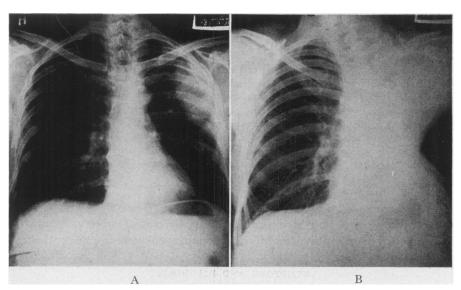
(A) Case 7: Regular PA roentgenogram of chest showing large peripheral squamous cell carcinoma of the lung, left.
